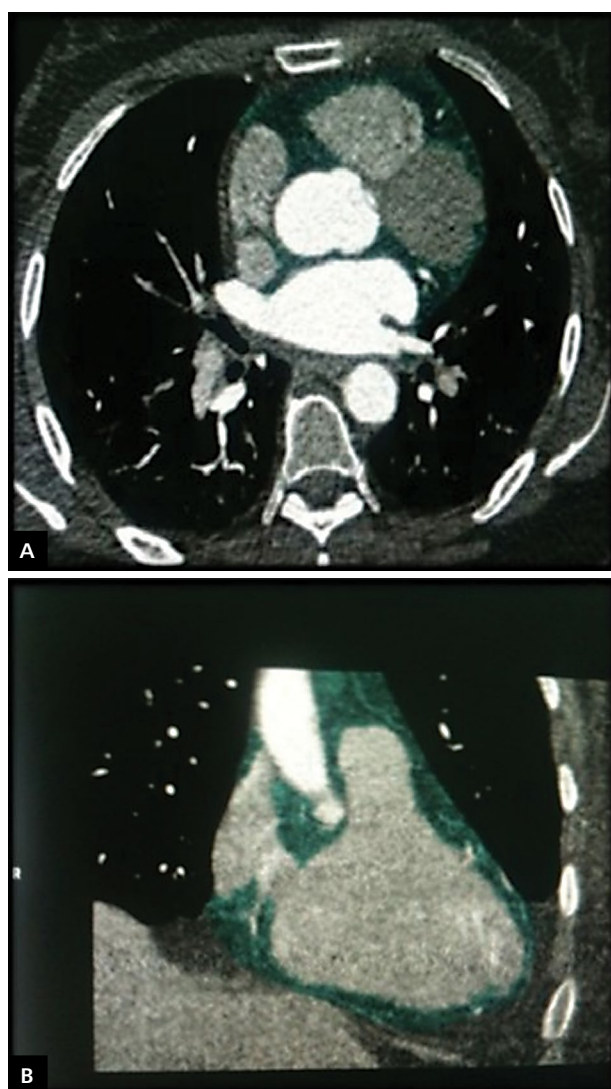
Measurement of pericardial fat volume (green shading) by multi-detector computed tomography in the (A) axial and (B) coronal sections of the heart
